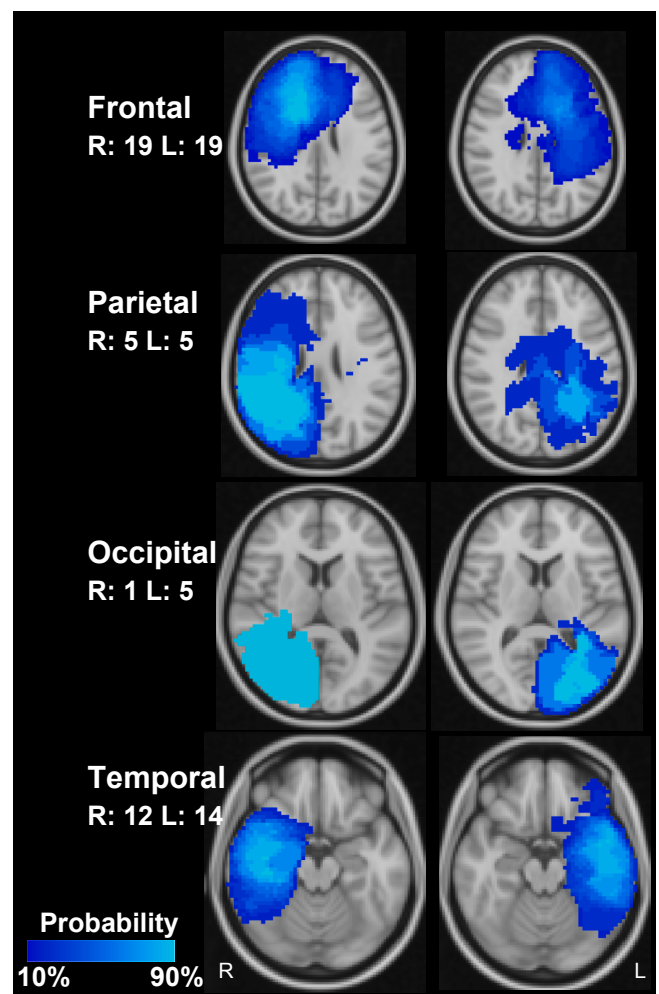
Lesion probability maps (comprising residual or recurrent tumor and treatment-related tissue changes in structural MRI and FET-PET images) for tumors located in the main lobes of the brain depicted in MNI-152 space. For each lobe, the image plane with the approximate focus of the lesions is shown. R: Right, L: Left, numbers: number of patients.
